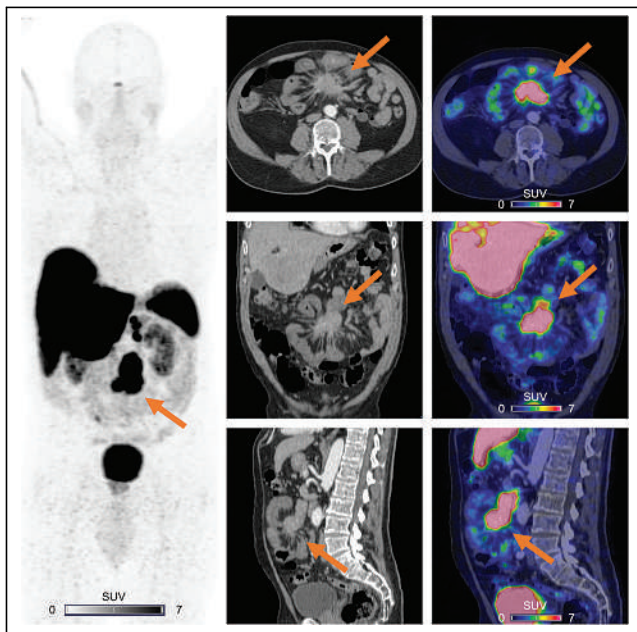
Baseline ^{68}Ga -DOTATOC PET (left), CT (middle), and PET/CT (right) images of 61-y-old patient presenting with typical retractile MM surrounded by linear bands radiating into mesenteric fat (arrows) that were intensely hypermetabolic (Krenning score 4).
